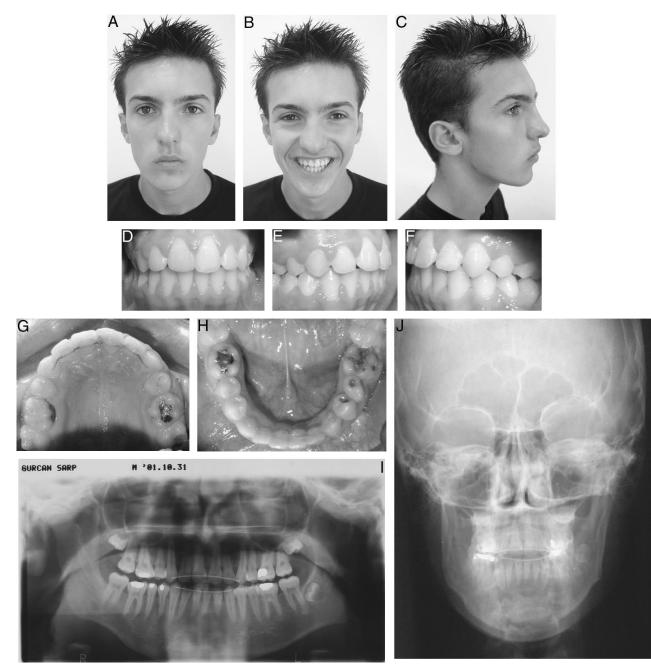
(A–J) Final extraoral and intraoral and radiographic views of the patient.
